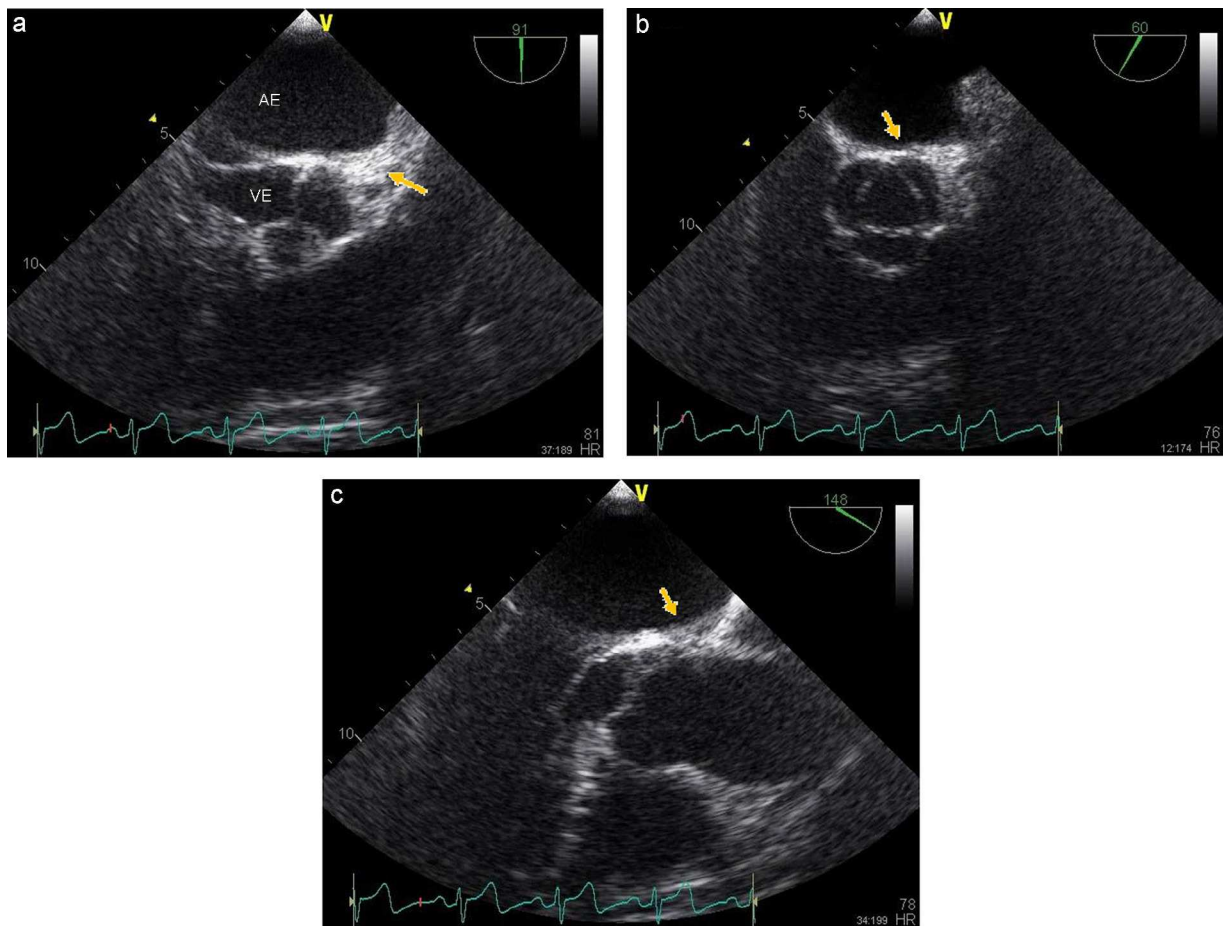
Echocardiogram showing the lesion. AE: left atrium; VE: left ventricle.
